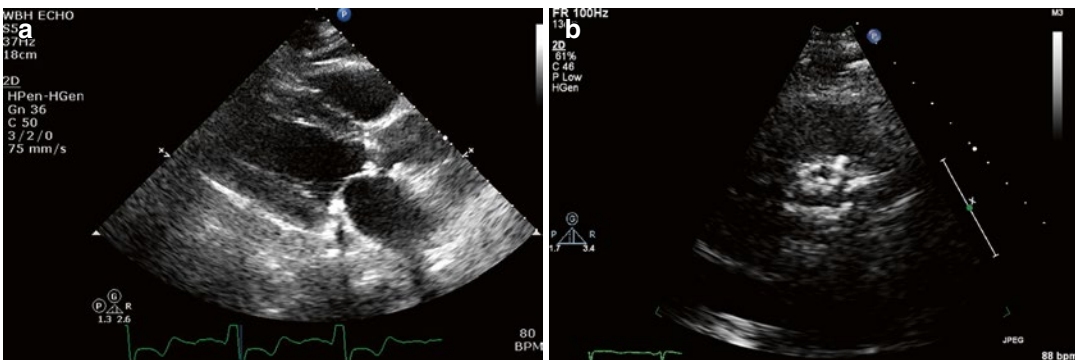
Parasternal long axis (a) and short axis (b) taken during ventricular systole. As opposed to normal, thin pliable leaflets, the aortic valve depicted here is thickened
